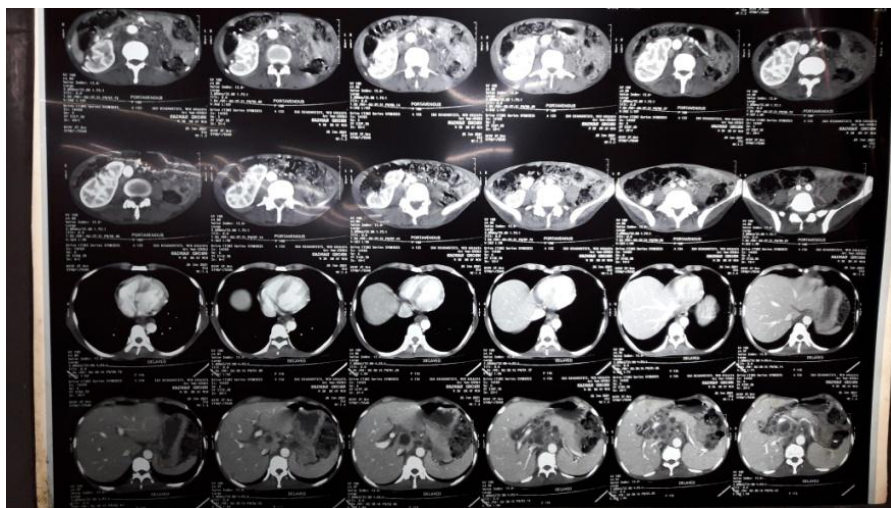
CT abdomen focusing crossed ectopic fusion of kidneys on right side.
